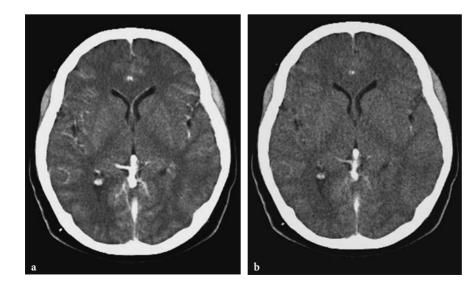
CT images of a 43-year-old woman with persistent headache for 3 weeks show normal brain struc-tures at the level of the basal ganglia. Standard brain CT after intravenous iodium contrast with a 6-MDCT at 130 kV, 280 mAs, 1 s rotation, CTDI=61.2 mGy, comparable to the "EC reference level" and standard dose level of the study of MULLINS et al. (2004). Calculated effective dose of the "standard" CT exam is 2.13 mSv; DLP=820 mGy·cm. a A 5 mm axial image with "standard" dose at 280 mAs and b an additional 5 mm axial image at low dose at 140 mAs: with 50% dose reduction the image is somewhat noisier but there is a clear delineation of the anatomical structures
